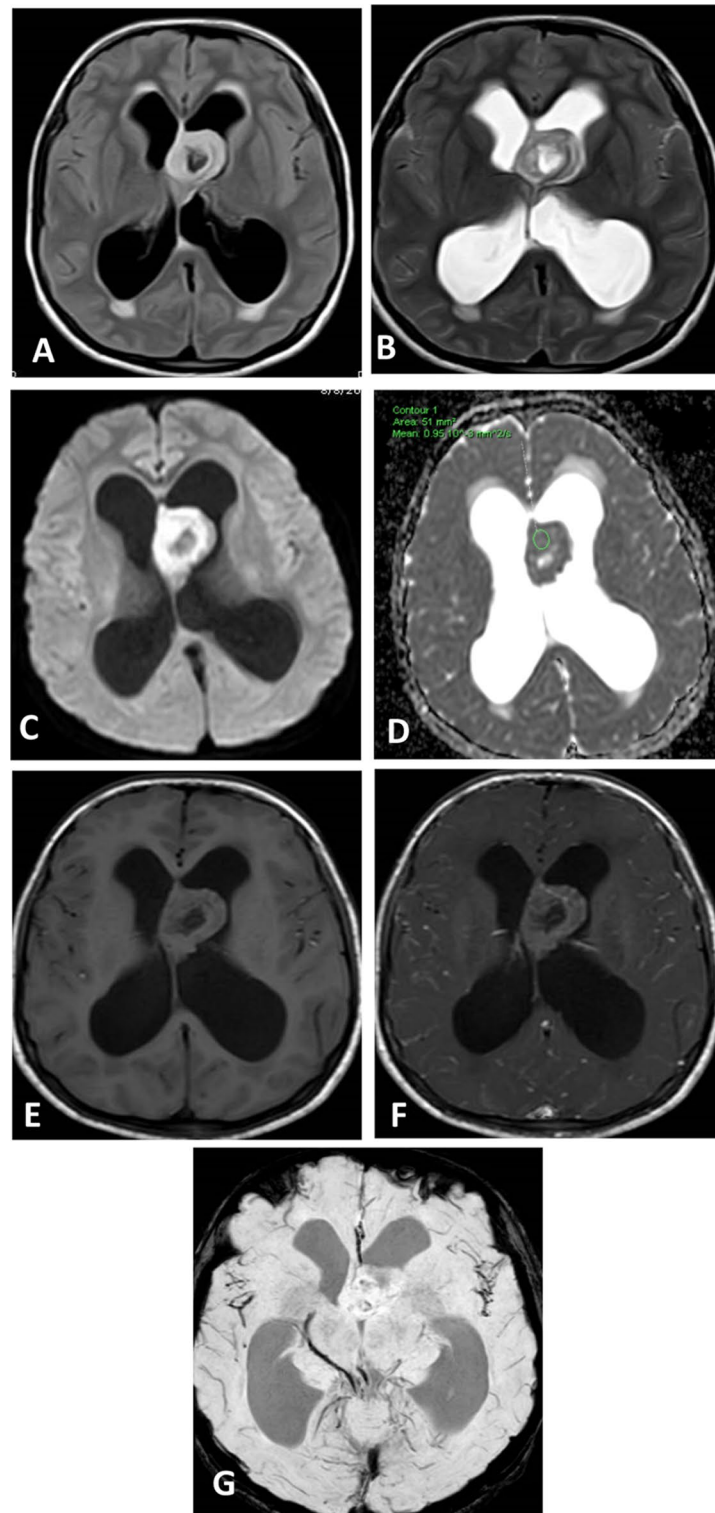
A 16-year-old male child with central neurocytoma. A Axial FLAIR and B T2WI show high signal space-occupying lesion based on the septum pellucidum causing obstructive hydrocephalus. C Axial DWI and D ADC show diffusion restriction with low ADC value measuring $0.95 \times 10^{-3} \text{ mm}^2/\text{s}$. E Axial pre-contrast T1WI shows isointense signal. F Axial post-contrast T1WI shows mild enhancement. G SWI shows more than 10 foci of hypointense signal (ITSS score 2)
